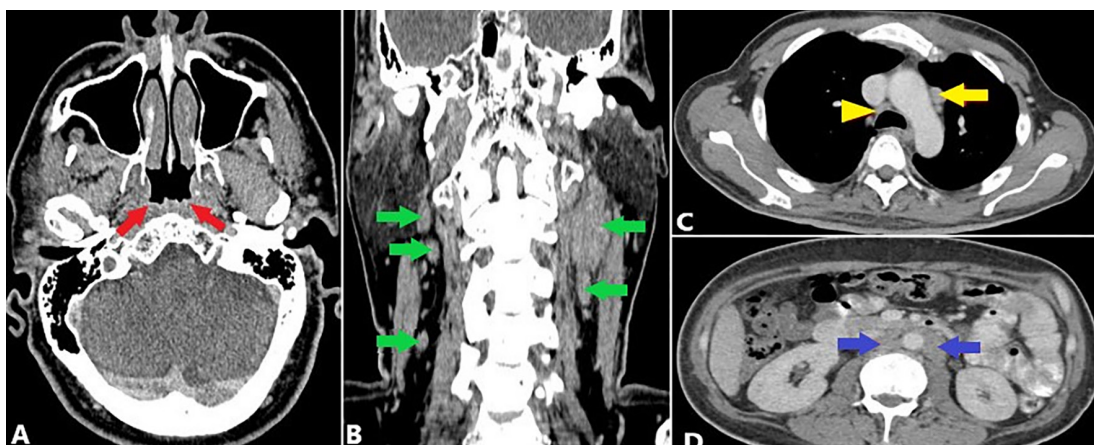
Contrast-enhanced CT scan of neck, thorax, and abdomen. Axial image at the level of the nasopharynx shows no enhancing lesion in the nasopharynx or the FOR (red arrow) (A). Coronal image of the neck shows bilateral cervical nodes at levels II, III, and IV (green arrow; B). An axial thoracic image depicts the right paratracheal LN (yellow arrowhead) and para-aortic LN (yellow arrow) (C). An Axial image of the abdomen shows para-aortic LN enlargement (blue arrow) (D).
